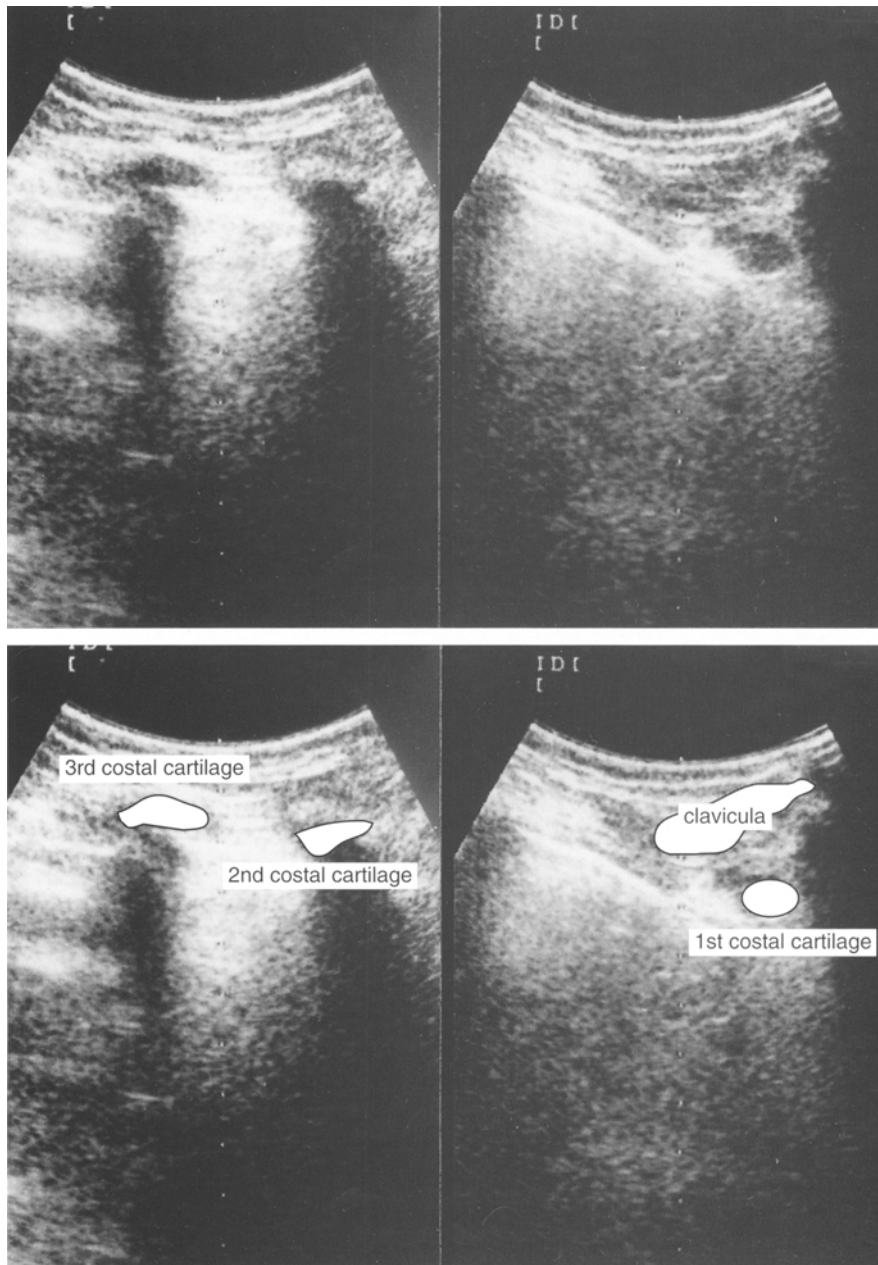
Sonography of left first, second, and third costal cartilage. The first costal cartilage has enlarged and swollen into a circle
